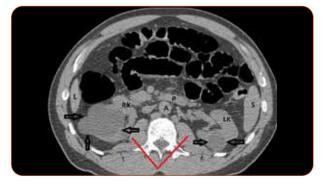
Unenhanced axial CT scan showing bilateral renal cysts (open black arrows). Right kidney (RK), left kidney (LK), liver (L), pancreas (P), spleen (S) and aorta (A). Psoas muscles (red lines).
